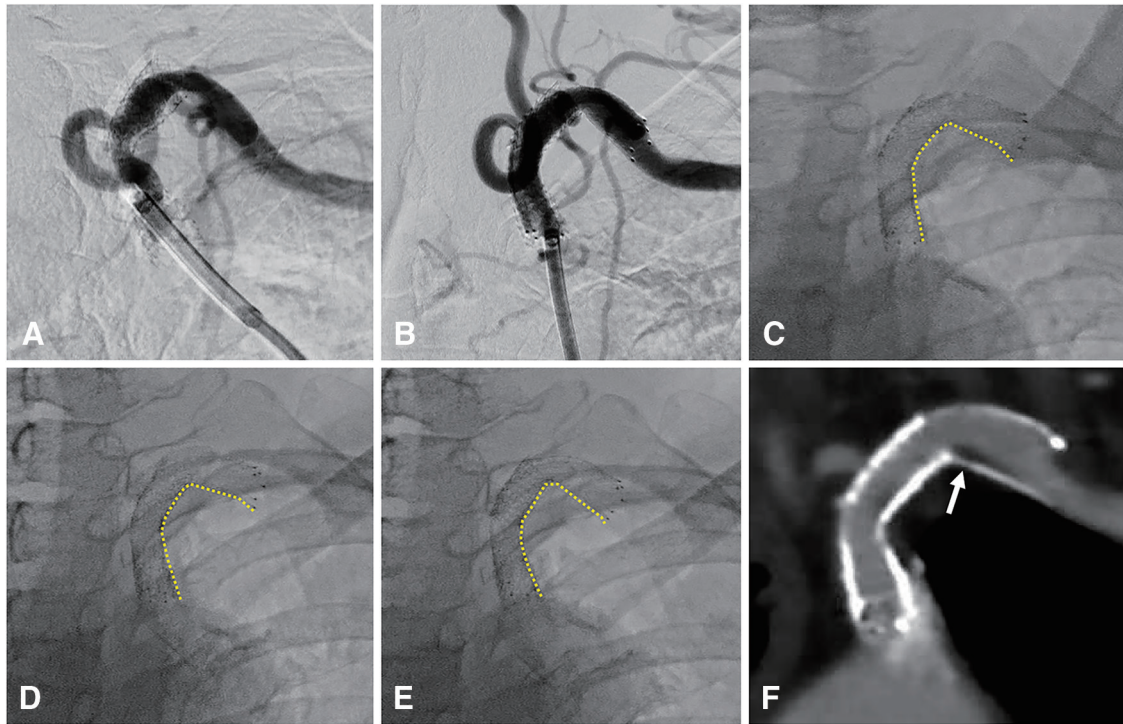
Preoperative angiography at the time of the second PTAS shows slow flow in the VA and in-stent stenosis due to stent fracture and intimal hyperplasia (A). Postoperative angiography of the second PTAS shows that the in-stent stenosis and blood flow in the VA have improved (B). Follow-up fluoroscopy the day after the second PTAS shows no stent deformation. In addition, the implanted stents do not show a hinge motion with upper limb movement (C and D) but have an apparent hinge motion with SCA pulsation (D and E). Follow-up CTA on the coronal section image two years after the second PTAS shows excellent patency, no stent re-fracture (F), but mild intimal hyperplasia at the site of hinge motion (white arrow). CTA: computed tomography angiography; PTAS: percutaneous transluminal angioplasty and stenting; SCA: subclavian artery; VA: vertebral artery
